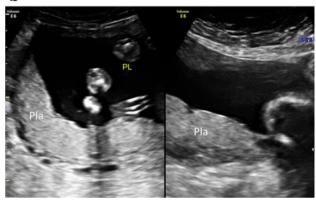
a Second trimester transabdominal ultrasound of placenta in relation to Cervix. Pla placenta, *Int Os* internal Os, *Ext Os* external Os, *Cx* cervix, *Bla* bladder. Dotted line – distance between the lower edge of placenta in relation to internal os. b Second trimester transabdominal ultrasound of placenta
